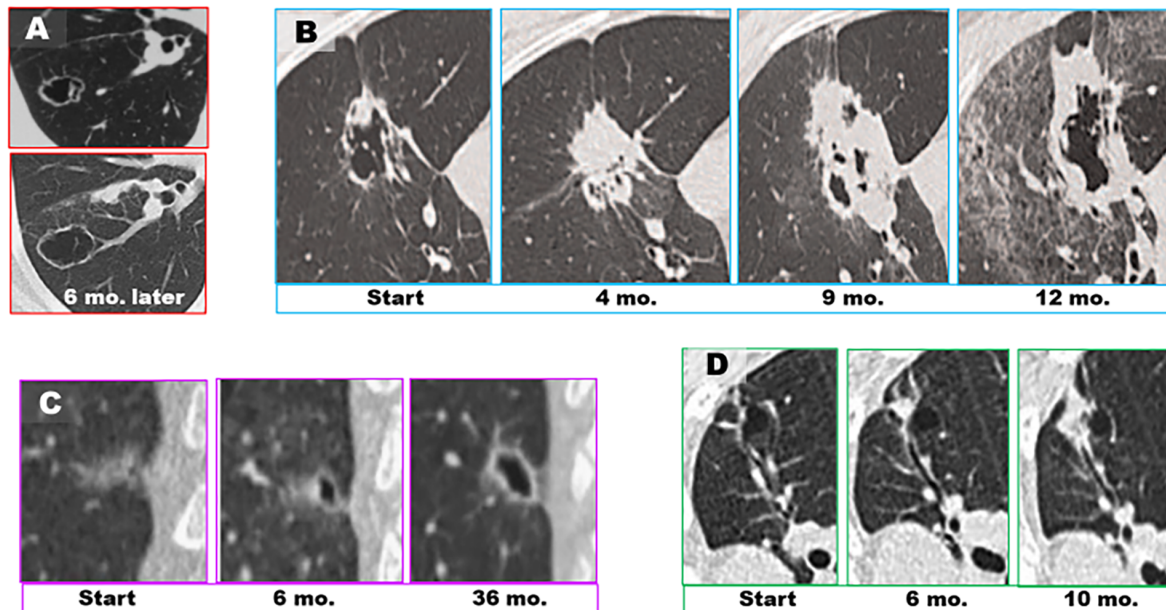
Representative CT images of cystic LCAL.
